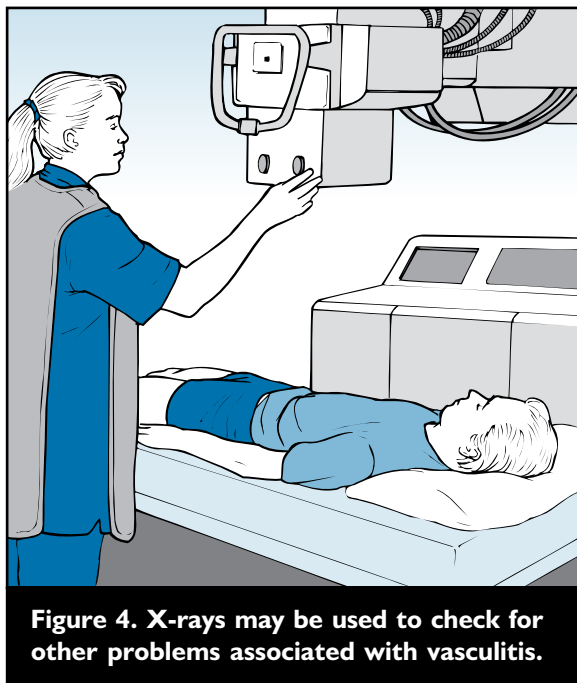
X-rays may be used to check for other problems associated with vasculitis.
